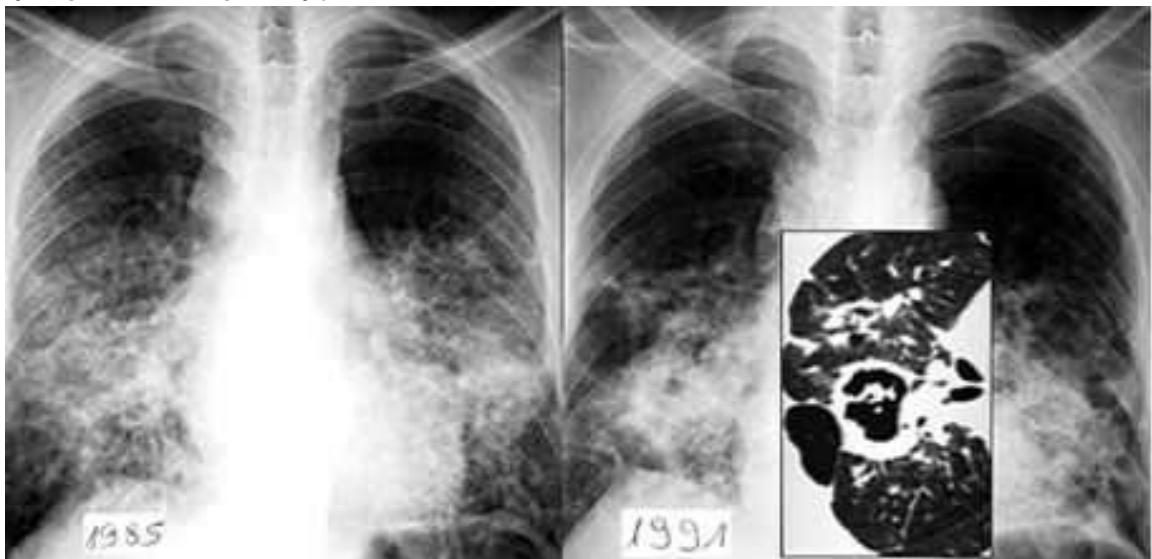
Radiograph: Pulmonary fibrosis.
